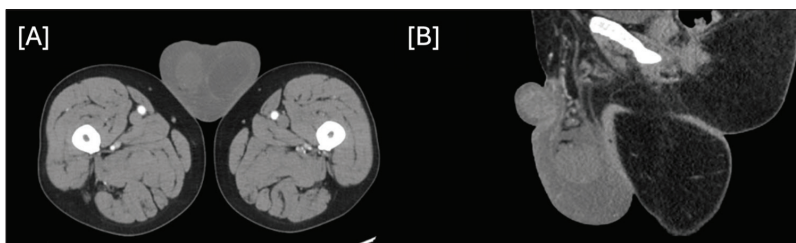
Computed tomography images demonstrating scrotal edema with diffuse soft tissue edema and free water accumulation in the scrotal region. Panel A shows an axial view, while panel B presents a sagittal view
